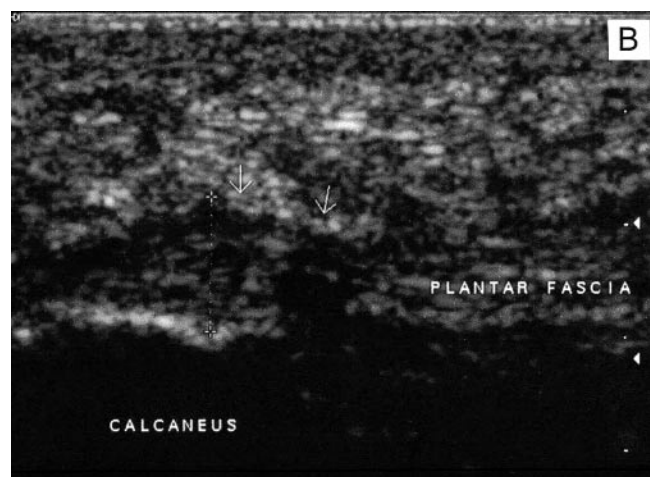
A. T2 weighted sagittal MR image of the heel showing no significant change of the plantar fascia thickness. B. US image showing increased focal thickness of the plantar fascia (0.59 cm), hypoechoogenicity at the calcaneal insertion, and presence of calcification foci (12 MHz).
